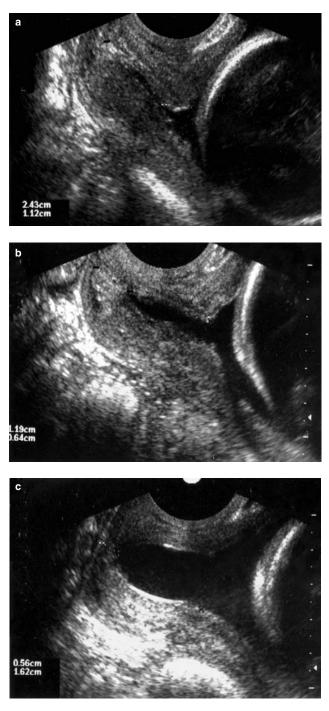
Transvaginal sonogram of a cervix of a twin gestation (25 weeks) (a) in the supine position and (b) after 1 min and (c) after 2 min in an upright position, demonstrating increasing opening of the internal os and shortening of the functional endocervical length
